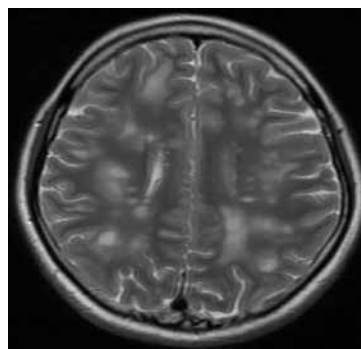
Repeat MRI of brain after one week showed regression of the lesions in T2 weighted images.
